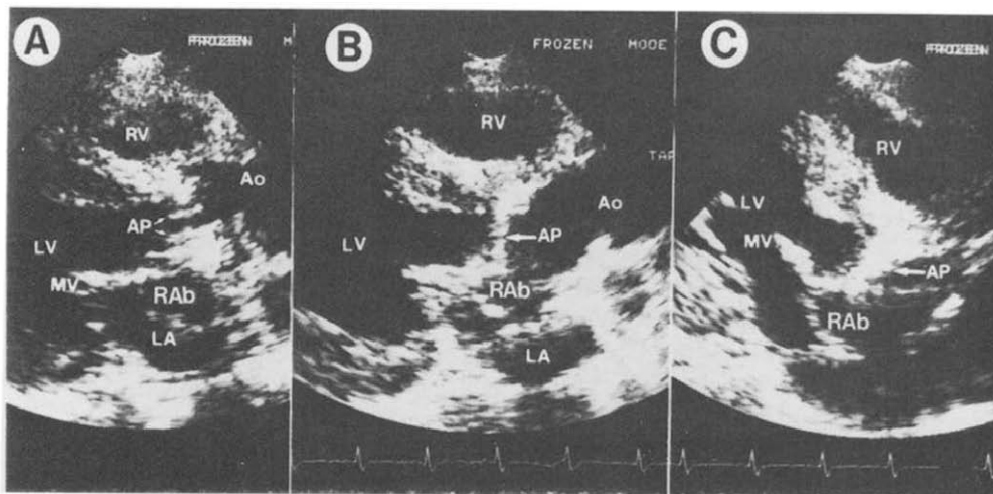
Case 3. Two-dimensional echocardiogram in a patient with a Björk-Shiley aortic valve prosthesis. A and B, Parasternal long-axis views show valve dehiscence as evidenced by rocking of the aortic prosthesis (AP) in systole (disc open) and diastole (disc closed), respectively. An echo-free space that represents the valve ring abscess (RAB) extends from the posterior aortic anulus into the anulus of the mitral valve (MV). C, Apical long-axis view shows the relation of the valve ring abscess (RAB) to the mitral valve (MV) and aortic valve prosthesis (AP). Other abbreviations as in Figure 1.
